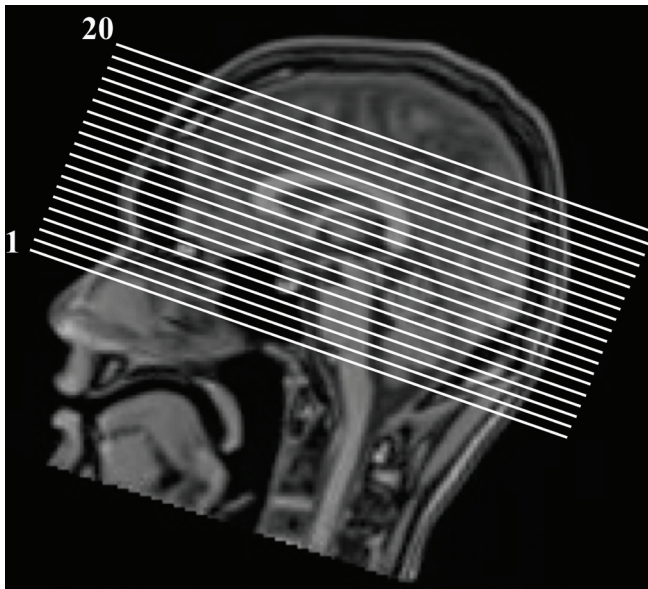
Example of the slice positioning for the DWI acquisitions used in this study. DWI, diffusion-weighted image.
